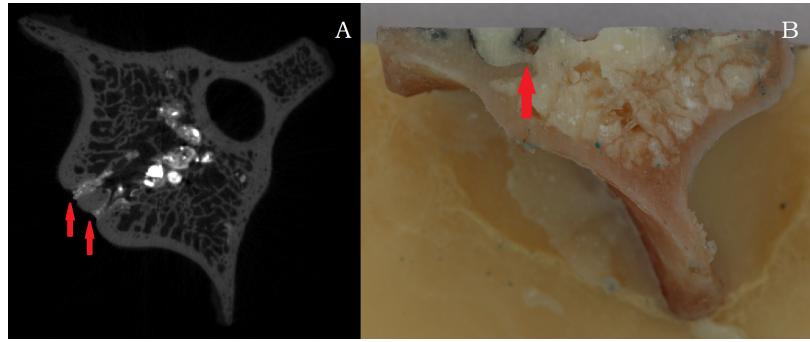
A: μ CT scan of an augmented vertebrae showing the cement leaking from vascular channels on the anterior side. B: Photograph of an augmented vertebrae cut into four quarters showing a vascular channel leading into the spinal canal.
